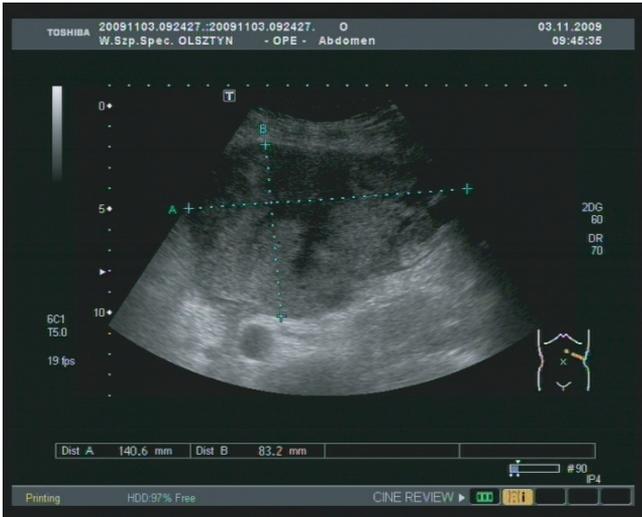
Abdominal ultrasonography. Tumor-like, cyst-structured lesion in the area of the pancreatic tail
